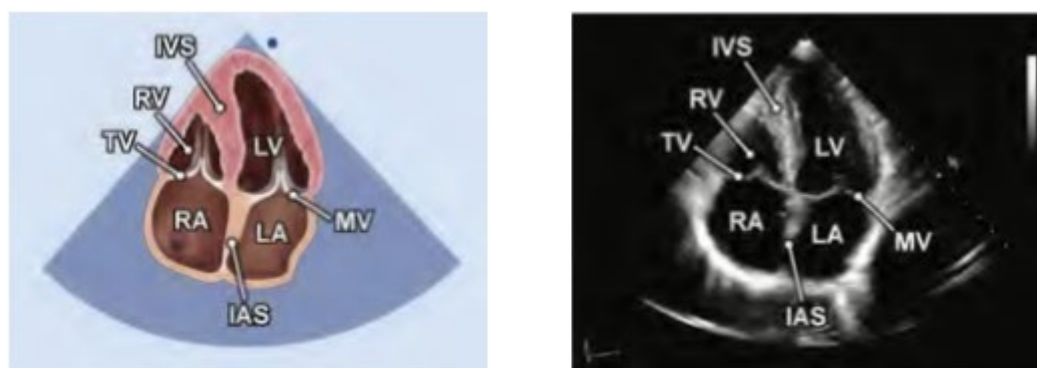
Apical four chamber view. Reproduced with permission from the American Society of Echocardiography. (135)
